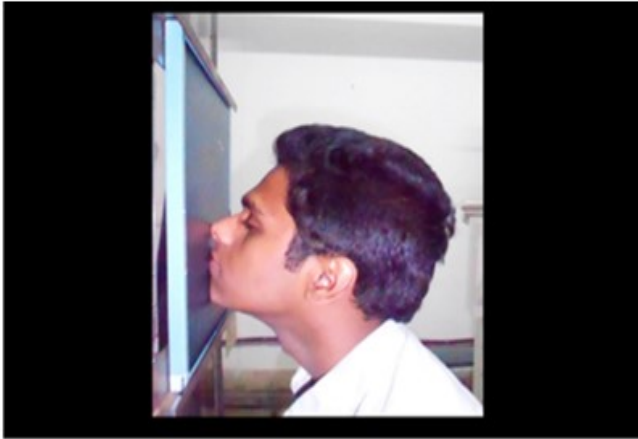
X-ray paranasal sinus – Occipitontental View (Waters View)
